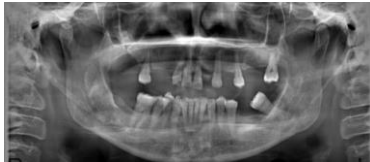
Panoramic radiograph shows bilateral elongated styloid process.
